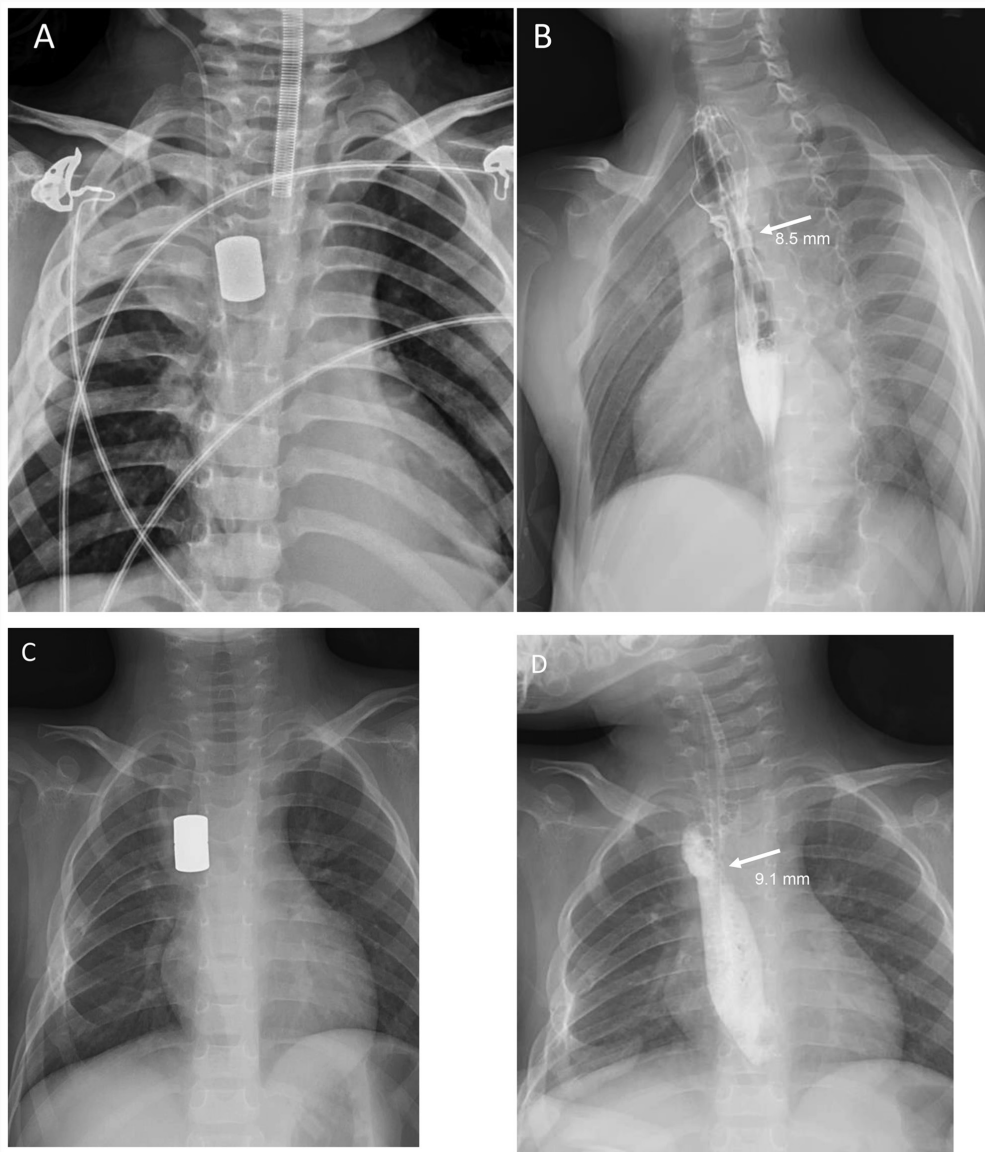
Chest radiography for the two patients. (A) Radiographic approximation was performed on day 1 for patient 1. (B) Magnets were removed and radiographic examination of the patient after magnetic compression stricturoplasty showed a patent esophageal lumen with an inner diameter of 8.5 mm at the anastomotic site on day 14 (arrow). (C) Radiographic approximation was performed on day 1 for patient 2. (D) Magnets were removed on day 18 and a widened lumen was maintained (an anastomotic stoma with an inner diameter of 9.1 mm; arrow).
